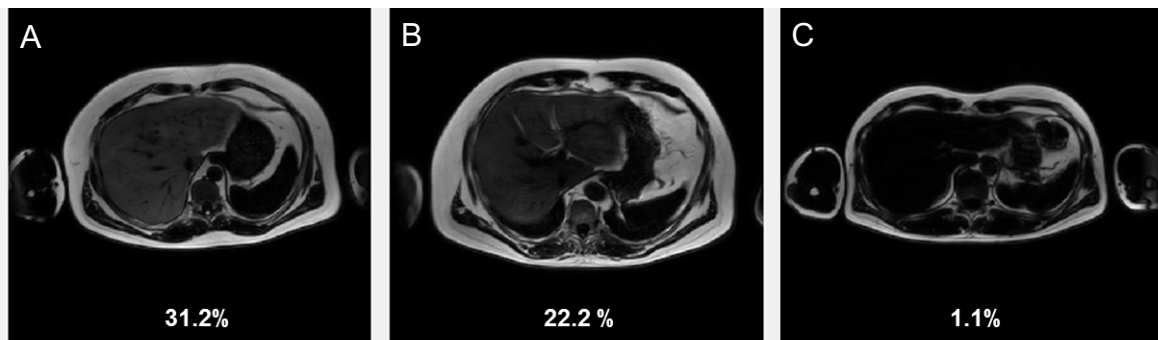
Representative MR images of liver fat content measured by PDFF. Differences in the liver fat content can be seen by appearing brighter with an increasing fat content. Presented are three male subjects with (A) a BMI of 29.20 kg/m², (B) BMI of 32.42 kg/m² and (C) BMI of 22.72 kg/m².
